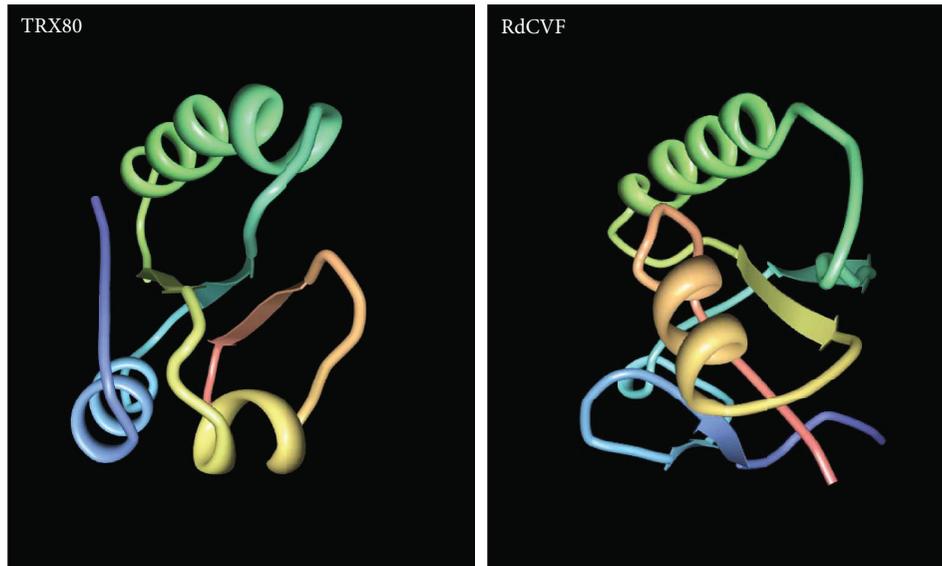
Structure models of TRX80 and RdCVF based on the X-ray structure of human TXN1 for TRX80 and on that of the thioredoxin TRYX of *Crithidia fasciculata*.
